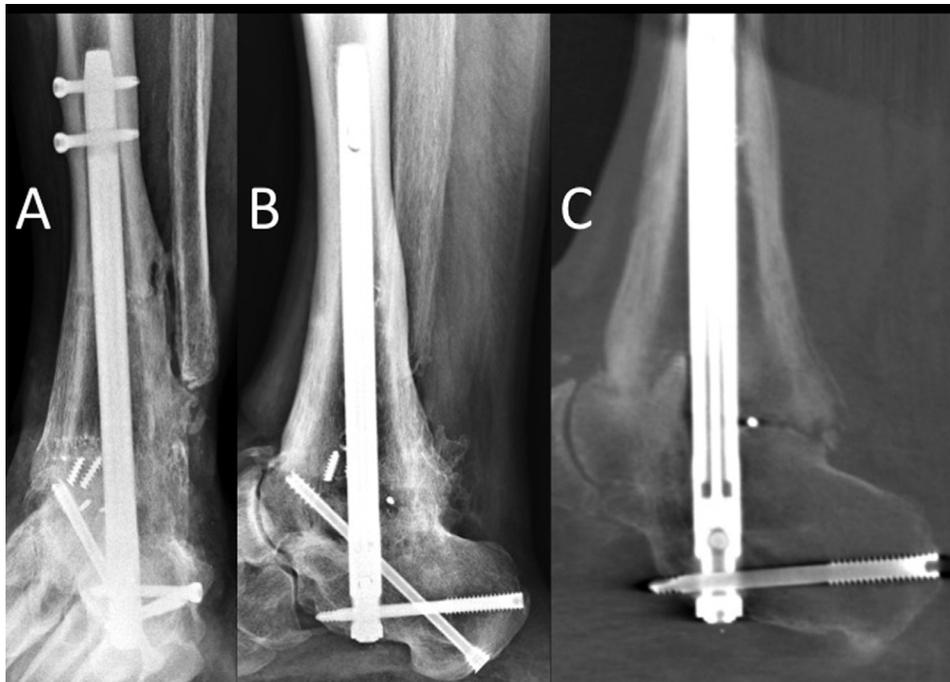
Case example imaging (patient BW). Final anteroposterior (A) and lateral (B) radiographs after revision tibiotalocalcaneal arthrodesis for persistent tibiotalar nonunion using a titanium intramedullary nail with an internal pseudoelastic nitinol compression element. Sagittal computed tomographic reformats (C) reveal complete bridging over the arthrodesis site anterior to the nail in addition to complete subtalar bony bridging from prior arthrodesis procedures.
